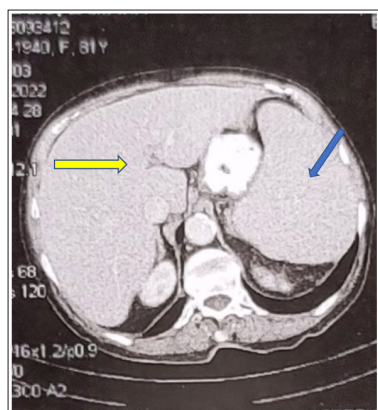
Sagittal CT view of the upper abdominal cavity, showing enlarged liver (left side, yellow arrow) and massive splenomegaly (right side, blue arrow), associated with enlarged hepatic hilum lymphnodes
